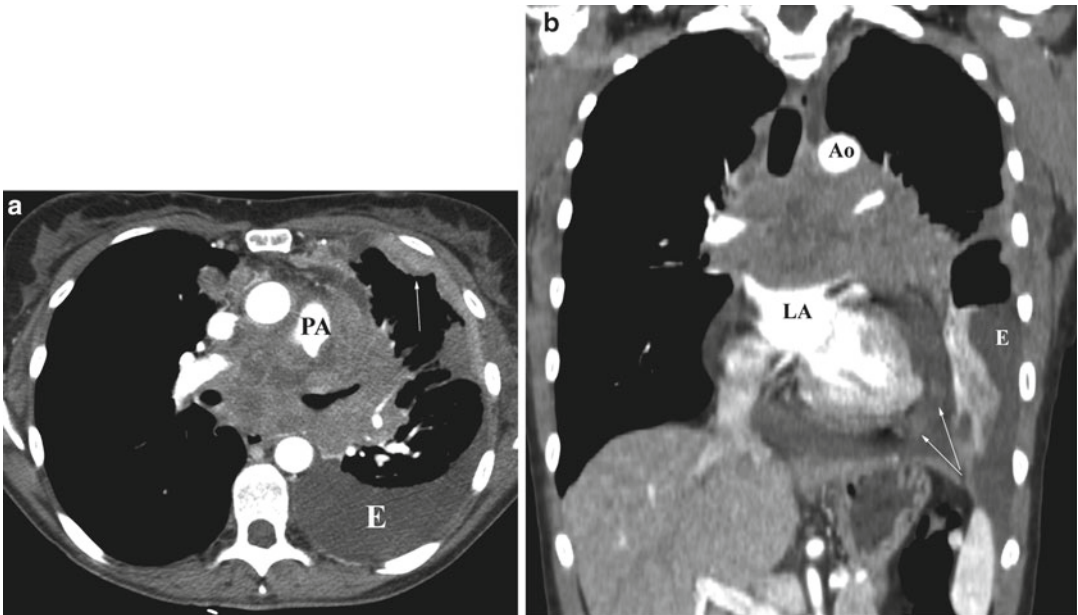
SCLC with pleural and pericardial metastases. (a) Axial CT image reveals large mass infiltrating the mediastinum and markedly narrowing the origin of the left pulmonary artery (PA). There is associated left pleural effusion (E) with metastatic pleural implants anteriorly
